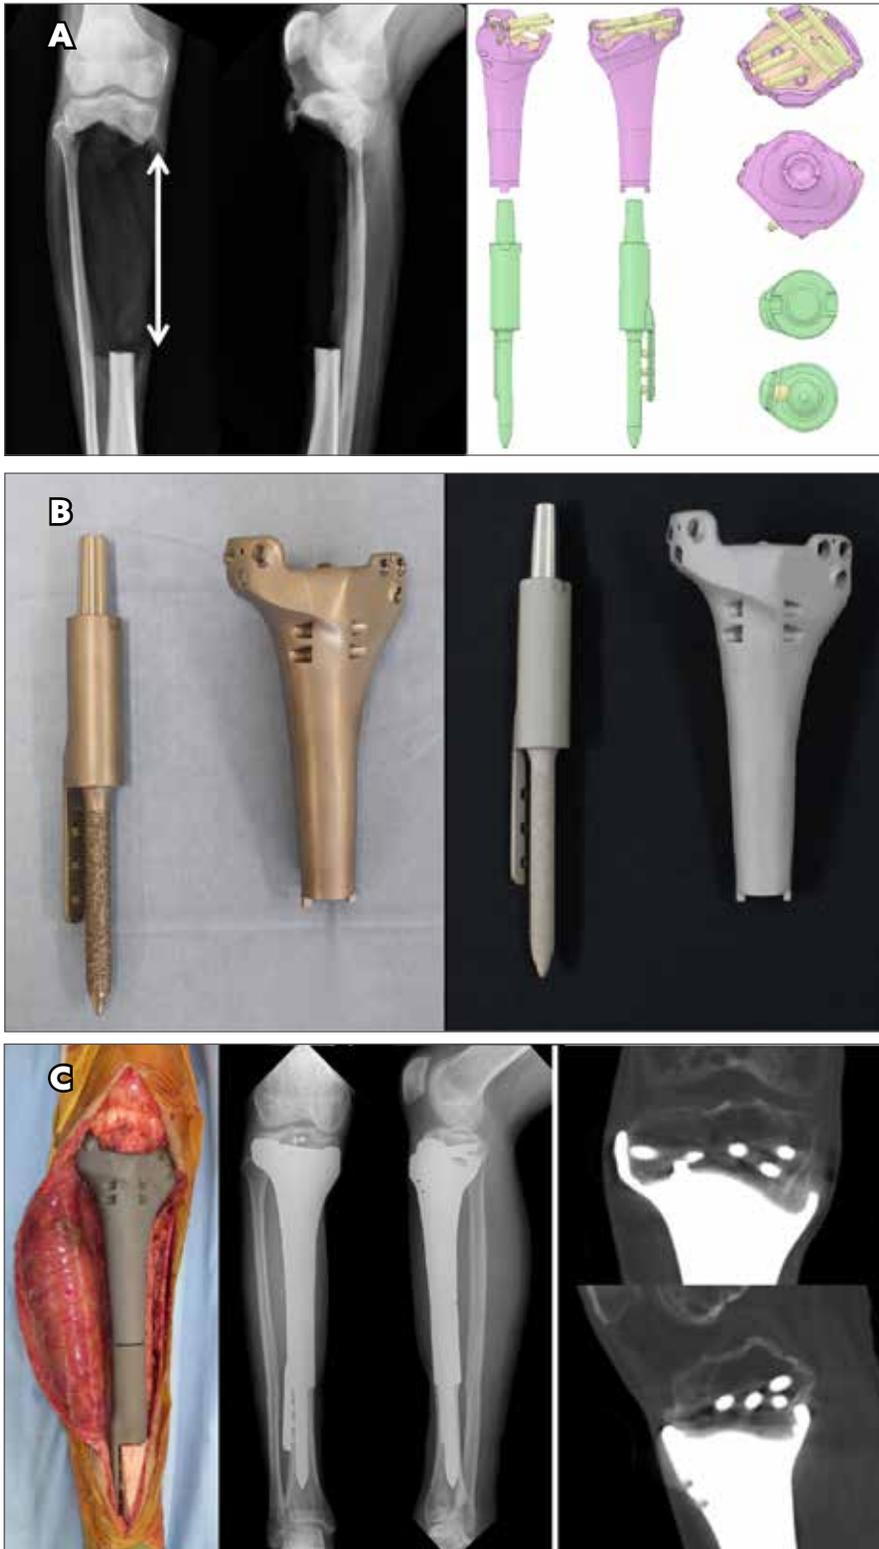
A to C. A. Left: 20 cm intercalary defect after tumor resection. Right: Custom-made implant with 3D printer. B. Left: Custom-made titanium implant with 3D printer. Right: The implant after surface modification with iodine (off-label). C. Left: intraoperative picture after reconstruction (off-label use), Center: Radiograph 1 year after operation. Right: Excellent bone ingrowth.
